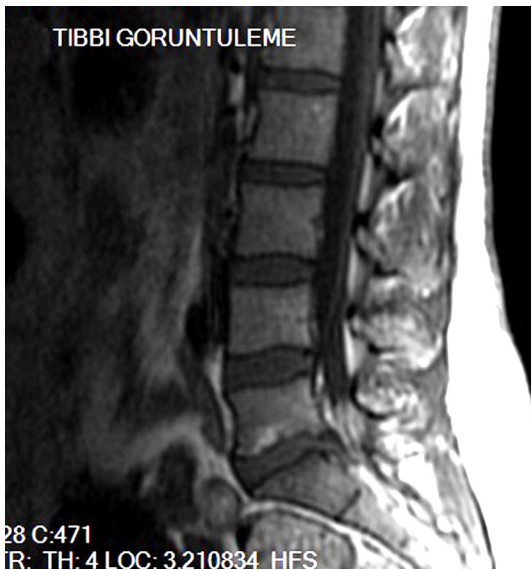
Sagittal (a) and axial (b) MR imaging of a degenerative disc disease.
